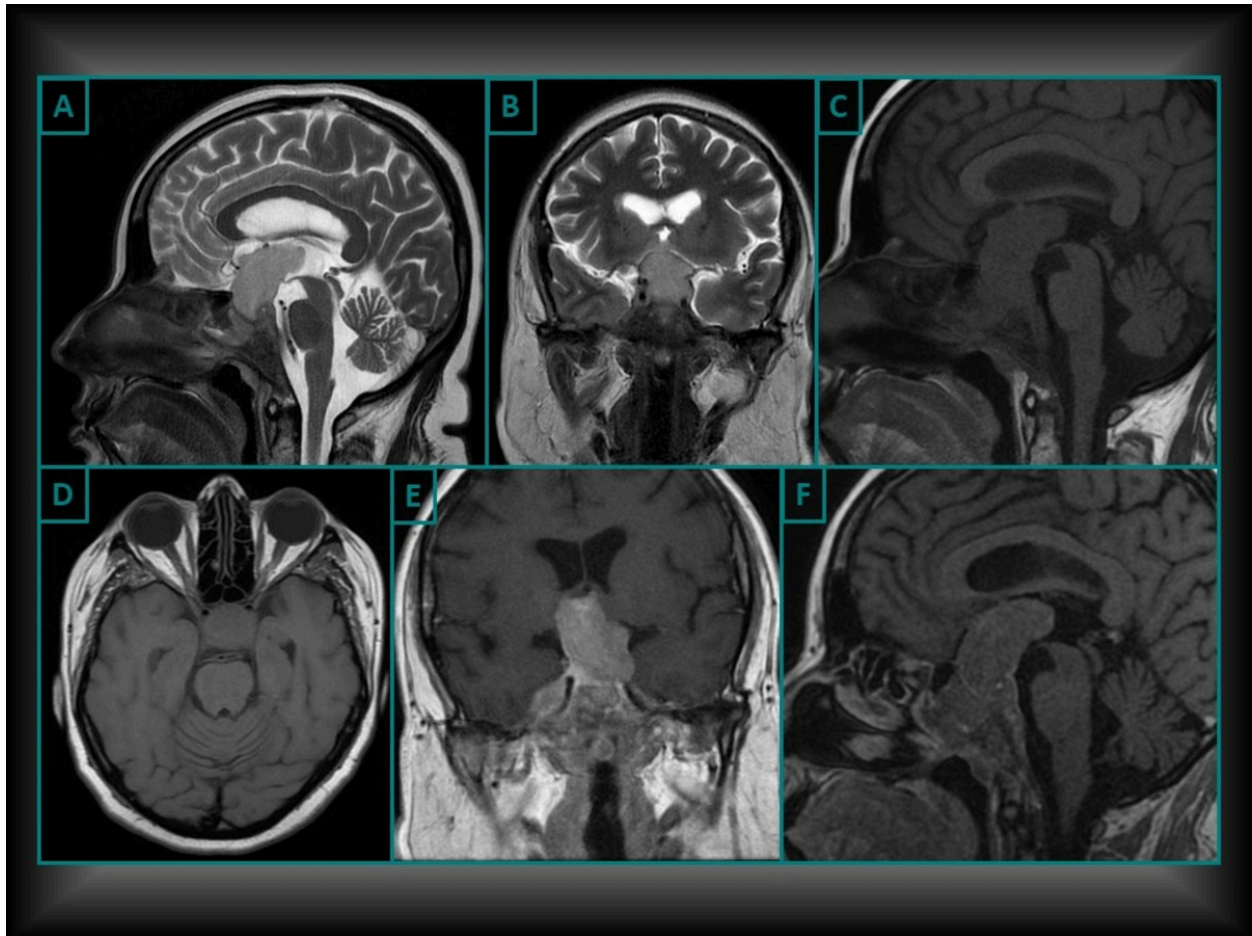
Pituitary Macroadenoma Coronal T1-W (A) and T1-W post contrast (B), Axial FLAIR (C) and sagittal T2-W images demonstrate an heterogenous enhancing mass lesion in sellar and important suprasellar location with compromise of a extension into paranasal sinuses.
